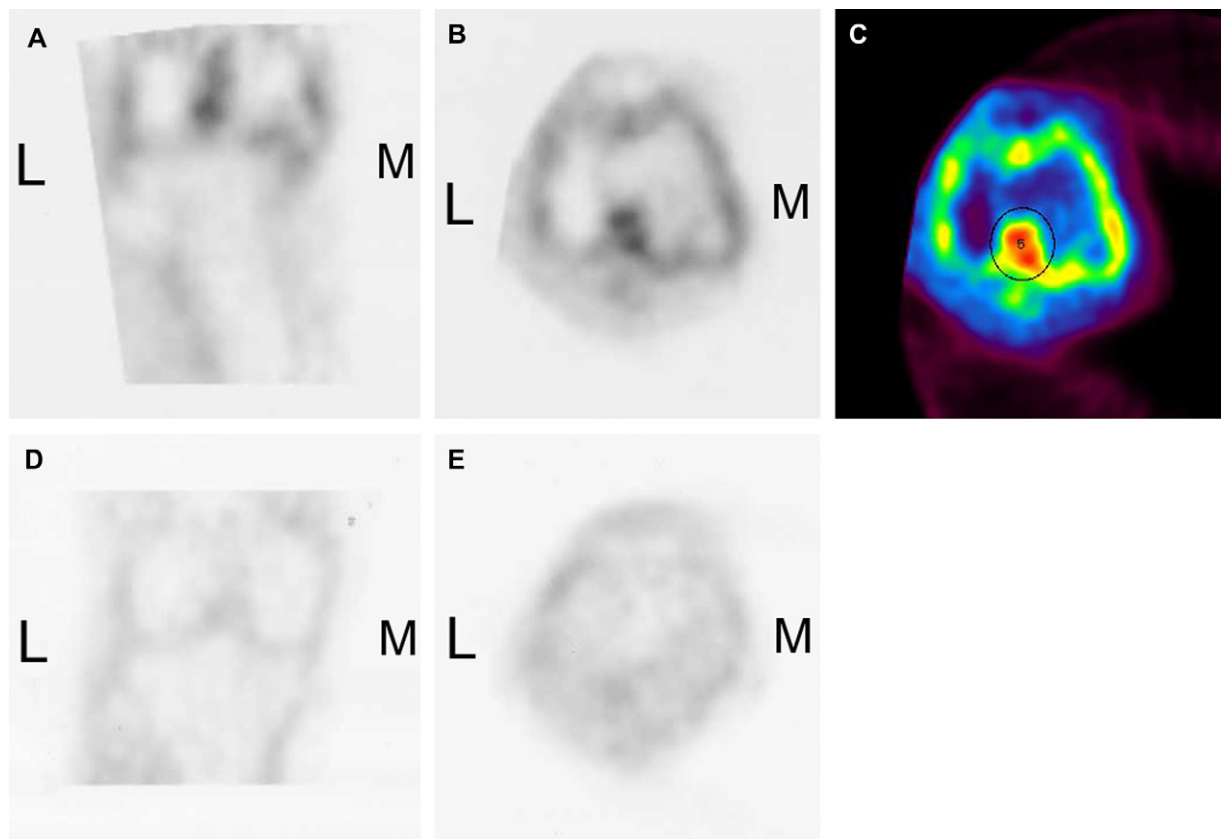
Representative coronal (A,D) and axial (B,C,E) sections of PET images in a knee with OA (A–C) and in a control knee (D,E).  $^{18}\text{F}$ -FDG uptake was emphasized by sequential colorization ranging from red (high) to blue (low) (C).  $^{18}\text{F}$ -FDG commonly accumulated in the periaricular region and was lacking in the articular cartilage. M: medial, L: lateral.
